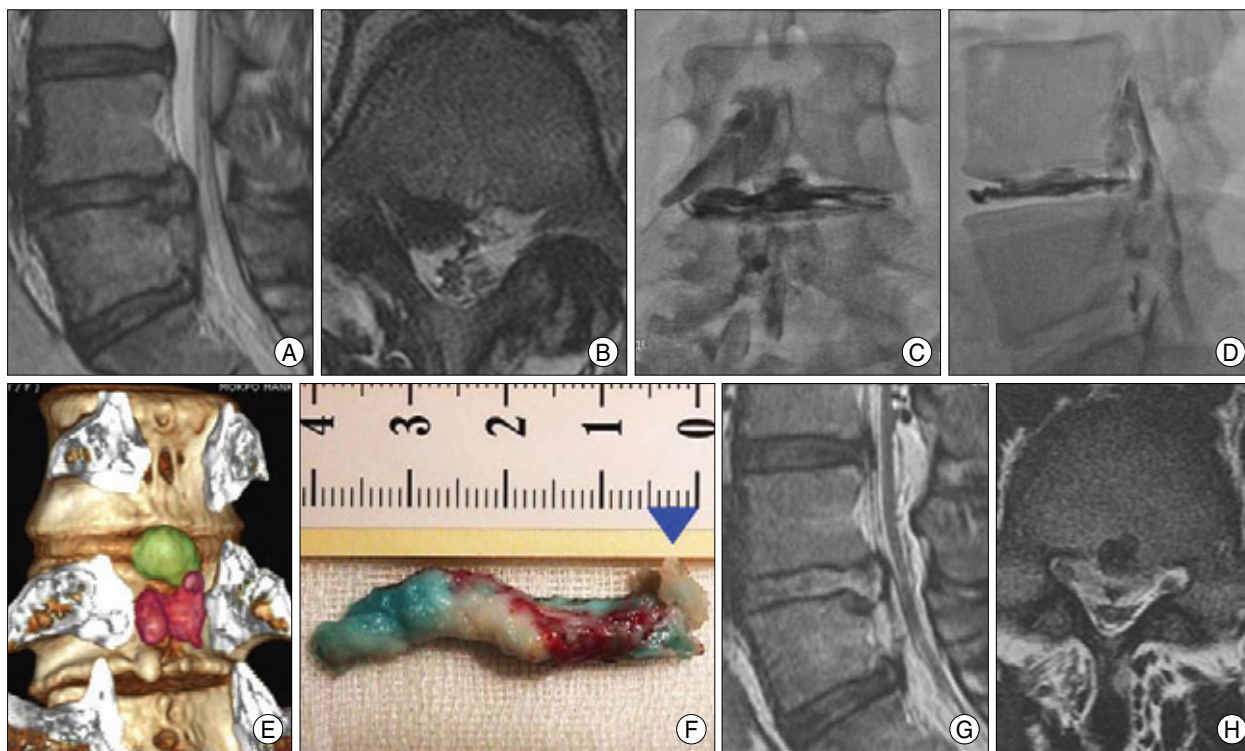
High grade inferior-sequestered disc type. Preoperative magnetic resonance (MR) image showing a large, high grade inferior-ruptured sequestered disc material (A and B). Preoperative discography shows dye leaks through the ruptured disc to the epidural space (C and D). There is a single piece of fragment on the disco-computed tomography image (E), even though it looks like multiple ruptured fragments on the preoperative MR image (A and B). Because it is possible to grasp the site of the stalk precisely (I and J : blue arrow), it can be removed sufficiently by the endoscope (G and H).
